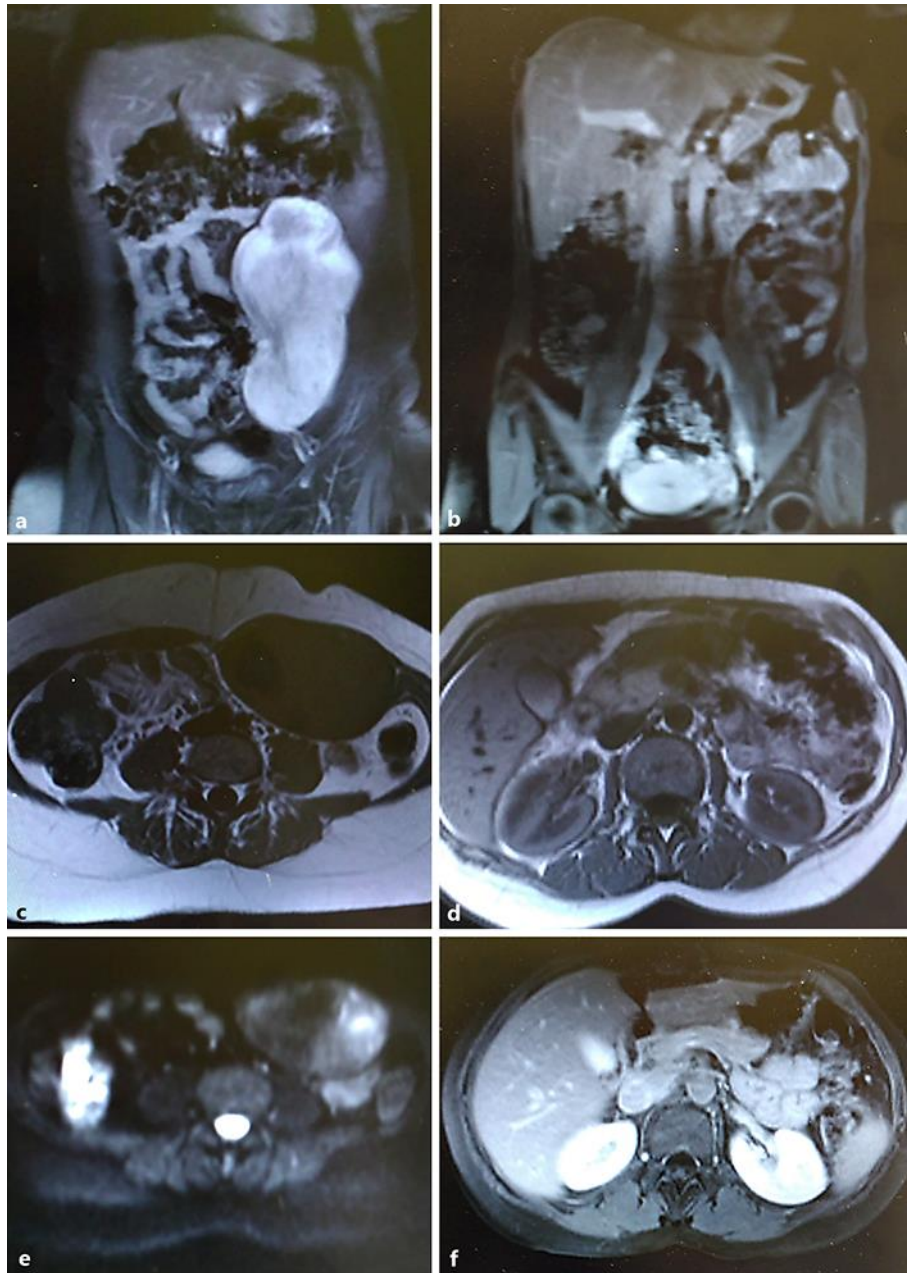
Preoperative body imaging study with MRI confirms the presence of a solid mass of about $18 \times 10 \times 6.4$ cm on the left abdominal wall: frontal section (a) and transverse plane (c, e). 12-month postoperative MRI shows no evidence of recurrence of the tumor or incisional hernia: frontal section (b) and transverse plane (d, f).
